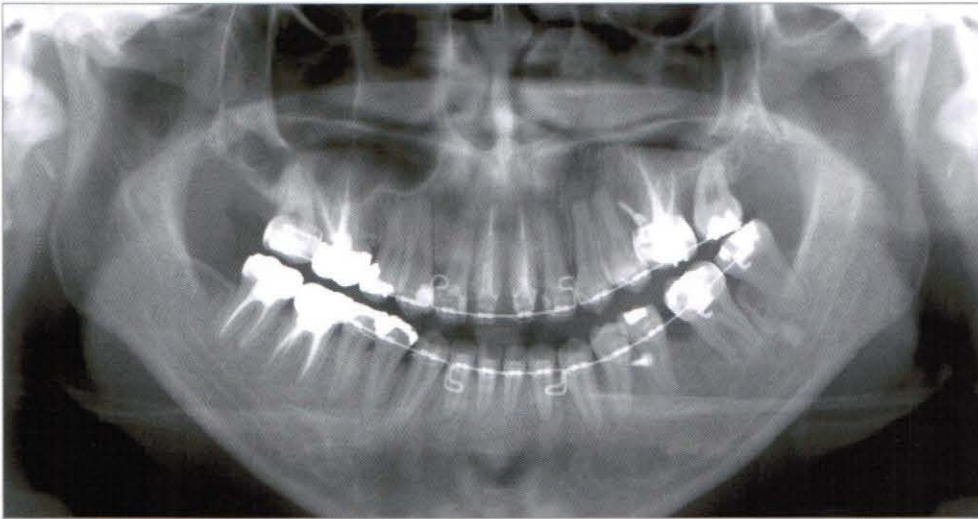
Panoramic radiograph at the space closing stage (2006, 4,6)
